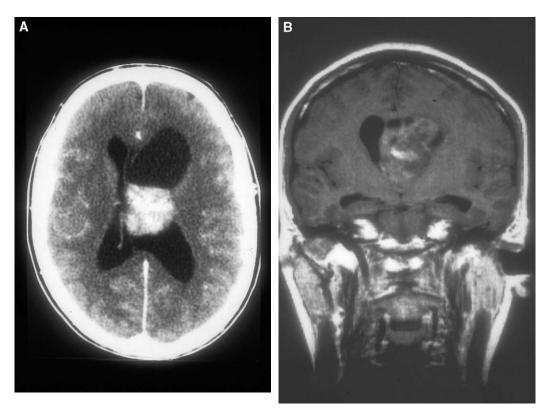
(A) Axial CT image with contrast. (B) Contrast-enhanced coronal T1-weighted MRI. (C) Axial T1-weighted MRI. (D) Sagittal T1-weighted MRI.
